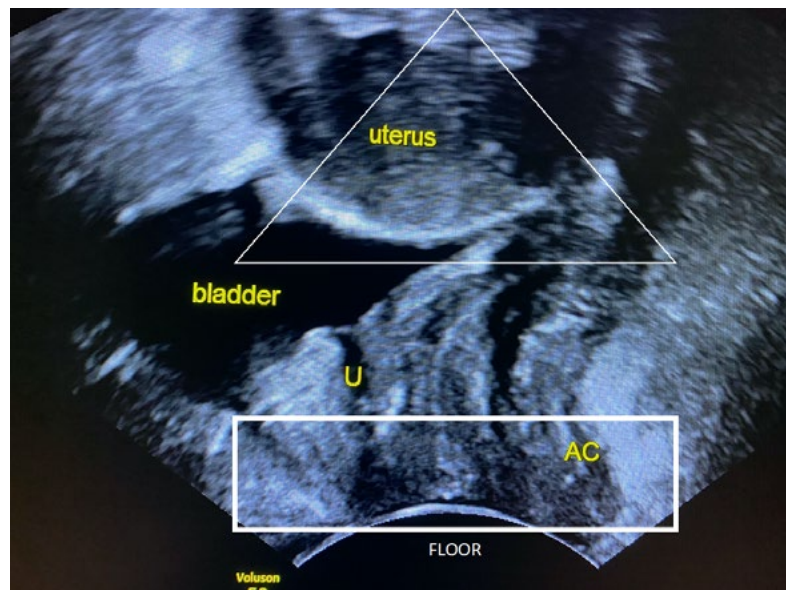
Transperineal ultrasound panoramic view with 2D midsagittal ultrasound. U - urethra. AC -anal sphincter complex.
